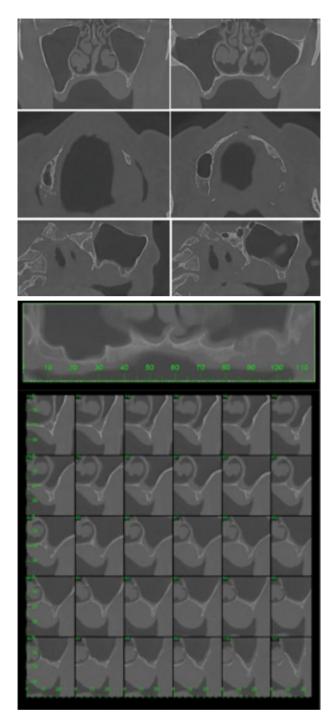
Multiplanar reformatted sections of CBCT show an extensive mass of soft-tissue density, continuing the hard palate region of the left side, causing a hypodense line of the maxillary sinus floor and the ipsilateral nasal fossa side wall, with irregular aspects of the bone adjacent to the lesion. Panoramic view and cross sections show the invasive aspect of the lesion with involvement and expansion of the cortical bone of the alveolar ridge, the floor of the maxillary sinus and left nasal fossa.
